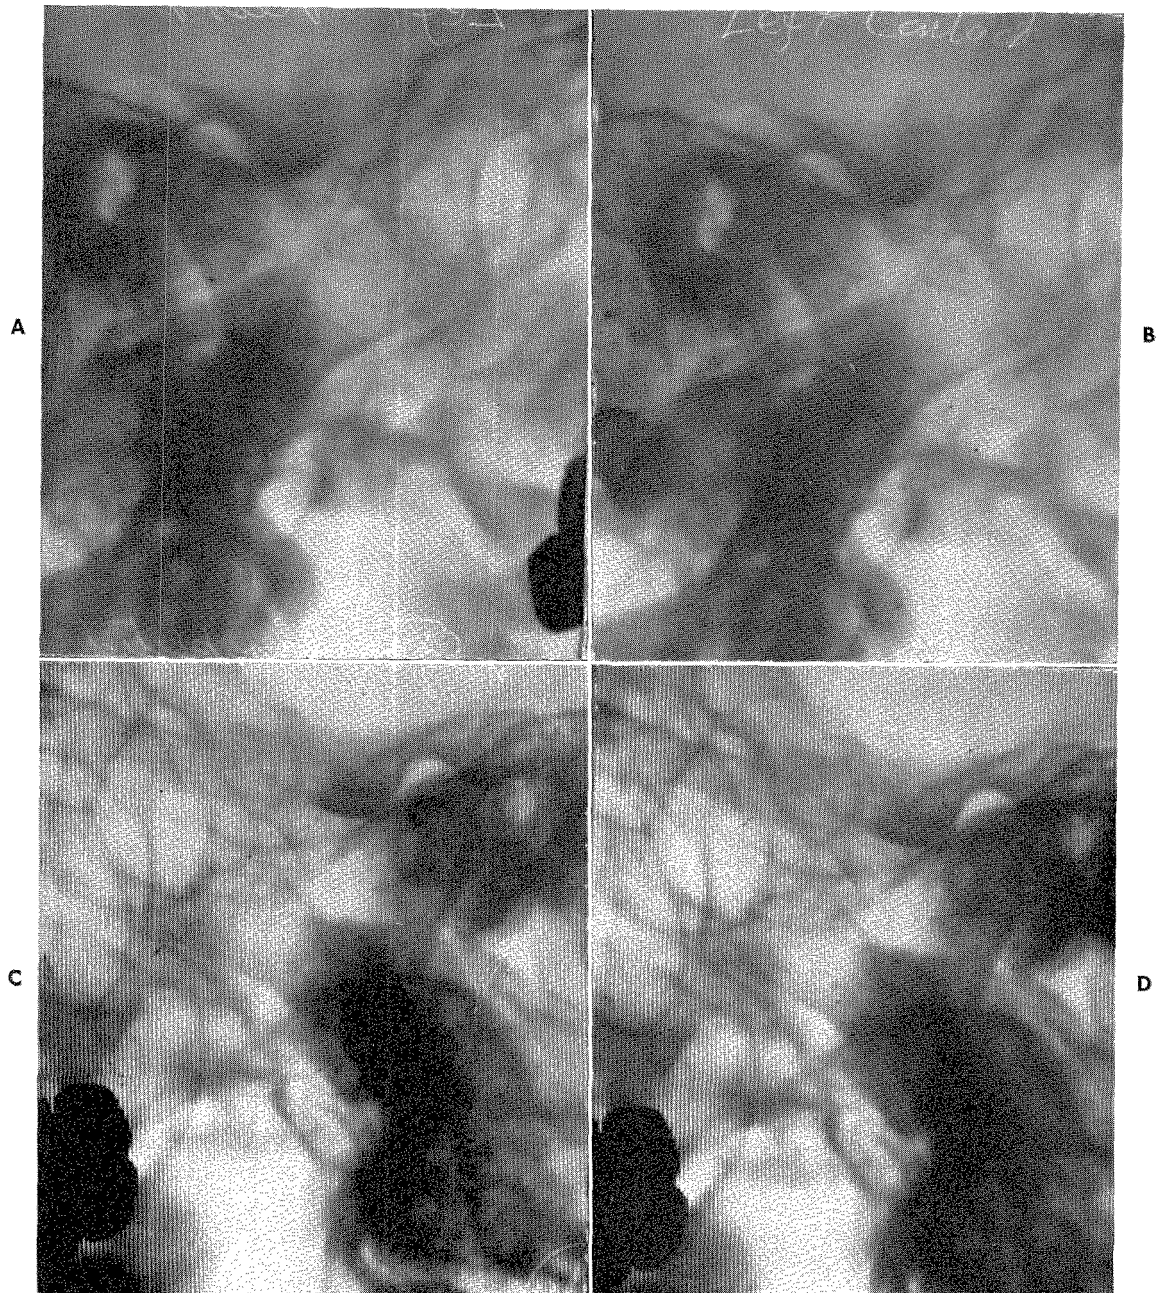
Roentgenograms of the right and left temporomandibular joints at the conclusion of treatment. A, Left rest position. B, Left contact position. C, Right contact position. D, Right rest position. Compare these with Fig. 995, A and B.
